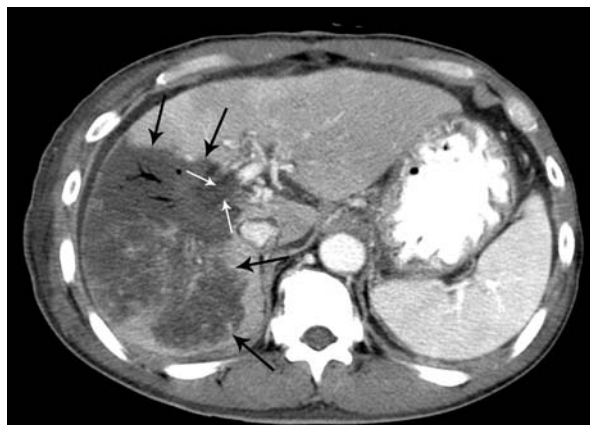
Hepatic lobar infarction-induced hepatic failure after intraoperative RF ablation. A 65-year-old man had been treated with intraoperative RF ablation for HCC measuring 3.0 cm adjacent to the central portal vein using a cluster-type internally cooled electrode without Pringle's maneuver. The patient had clinical features of hepatic failure after surgery; the CT scan on the ninth postoperative day revealed an extensive right lobar infarction (black arrows) of the liver with portal vein thrombosis (white arrows) from the main to the segmental branches. He refused liver transplantation and expired 1.2 months after the RF ablation.
